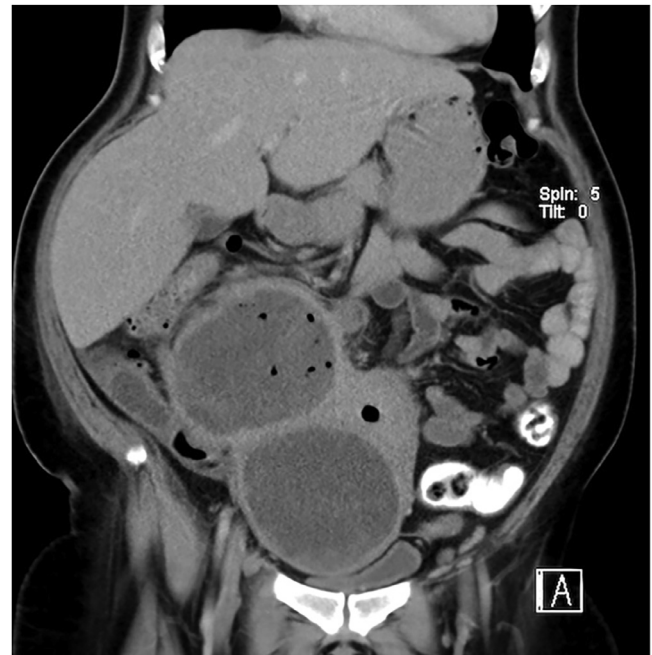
Coronal reformatted contrasted CT Abdomen showed 2 large well-defined wall enhancing complex cystic collections with intralesional air locules occupying the mid-abdomen and pelvis measures $8.7 \times 11.0 \times 9.8$ cm and $7.9 \times 9.0 \times 9.2$ cm (AP \times W \times CC) respectively.
